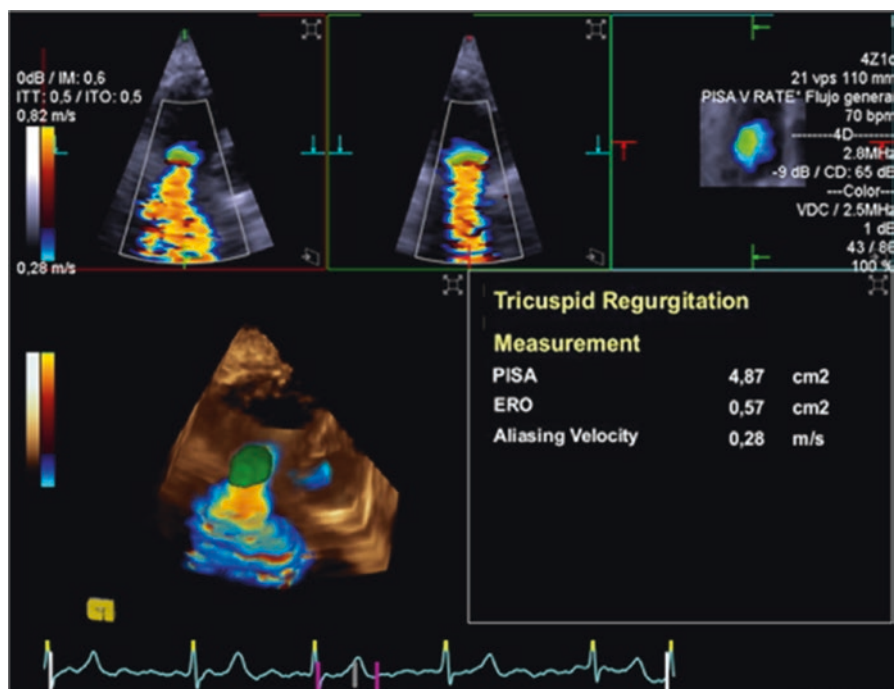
A multiplanar reconstruction of 3D-TTE dataset obtained via a single beat acquisition. 3D PISA is automatically extracted and displayed as green overlay on a 3D colour Doppler image (top, the three reference planes: left, four-chamber view; center, two-chamber view; right, short-axis view). Bottom left: 3D rendered PISA in the volume-rendered image. ERO: Effective regurgitant orifice. Modified from de Agustin et al. with permission [33]
